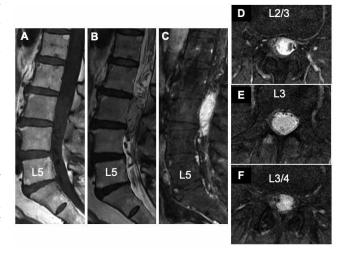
Magnetic resonance imaging (MRI) showing an intradural tumor at L3. (A) The lesion appears as an iso-intense area on sagittal T1-weighted imaging and (B) hyperintense with a low intensity area on sagittal T2-weighted imaging (T2WI). Serpentine vascular structures (area of flow voids on T2WI) distinguished from the cauda equina appear at both the cranial and caudal parts of the tumor. (C) Contrast-enhanced fat-suppressed (CE-FS) T1WI. The tumor shows strong gadolinium enhancement (D, E, F). Axial view of CE-FS T1WI. The tumor occupies the intradural space and flow voids are seen in and around the tumor.
